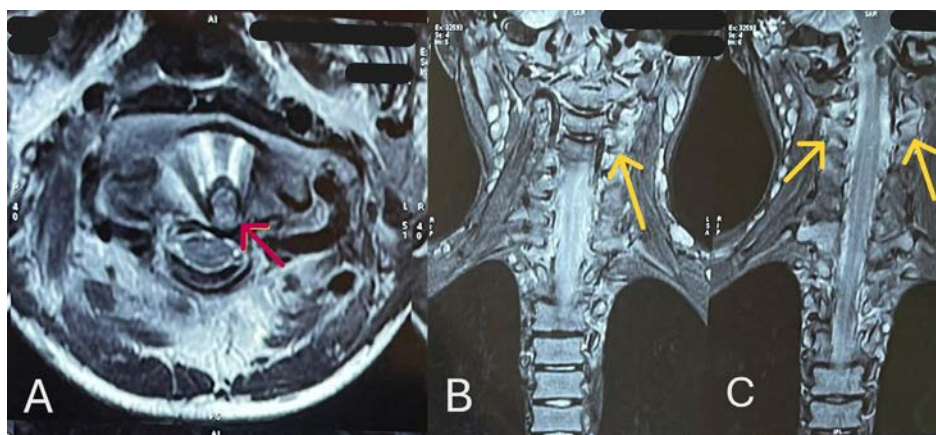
MRI of neck. (A) Axial view at C1/C2 level showing left posterolateral subluxation of dens (Red arrow). (B and C) Coronal STIR views showing facet joint edema and costovertebral enthesitis (yellow arrows) at C2/C3/C4 levels.
